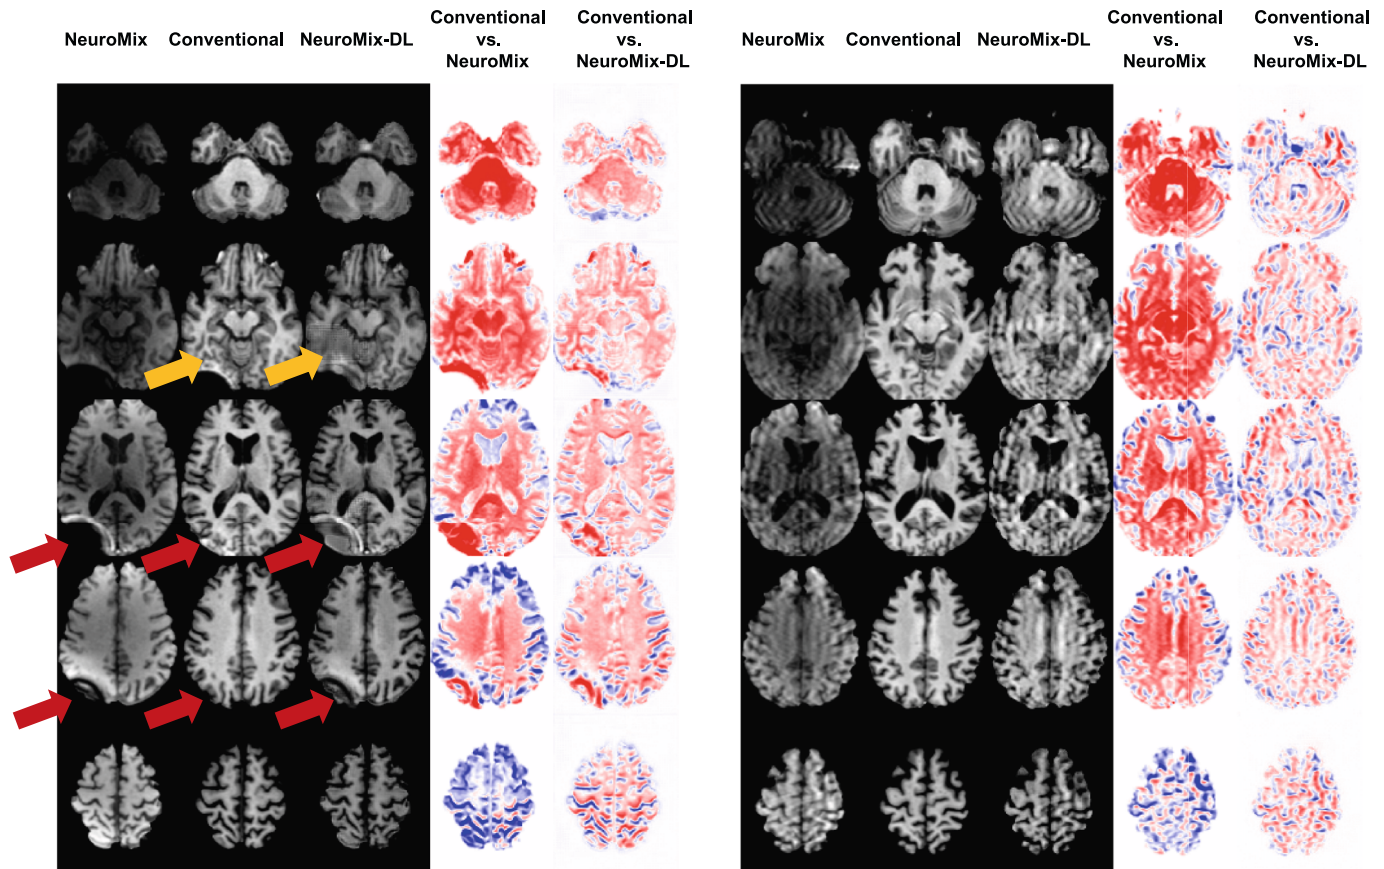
Artifacts seen in two subjects (A- 58-year-old female and B- 49-year-old male). The panel A shows a subject with artifacts on NeuroMix T1-weighted imaging from a right parietal ventriculoperitoneal shunt, which limits detailed evaluation of the surrounding brain parenchyma in the right parietal and occipital lobes (red arrow). For a few cases, the model causes a grid artifact for some slices (orange arrow). The panel B shows a subject with motion artifact during NeuroMix acquisition, which propagated to the model’s output. The fourth and fifth columns show the difference map between the conventional and NeuroMix images and conventional and NeuroMix-DL images. Difference color scale: -0.1 to $+0.1$; red = overestimation, blue = underestimation relative to the conventional image.
